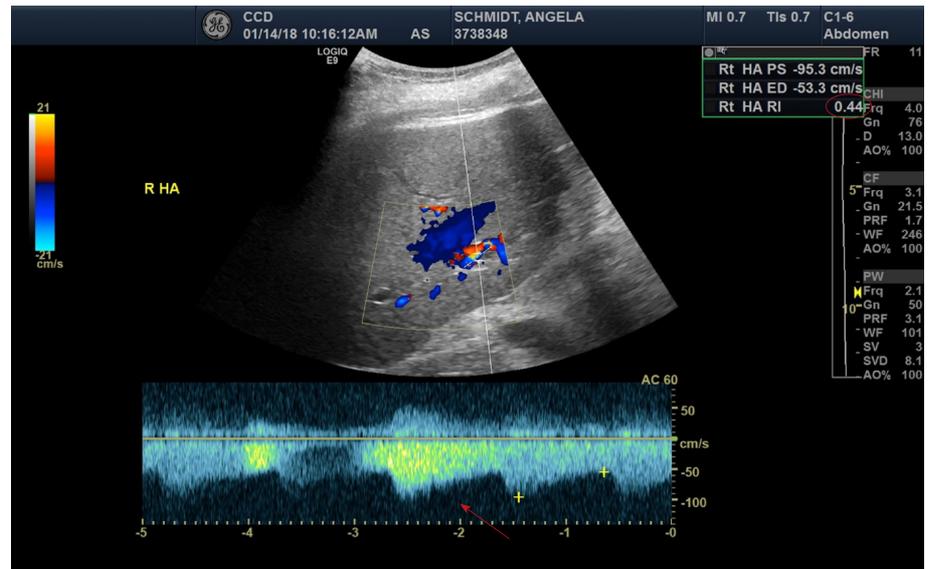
Liver ultrasound with doppler demonstrating increased diastolic flows (red arrow) and reduced resistive indices (noted to be 0.44 in the upper right corner, red oval) of the right posterior hepatic artery.
